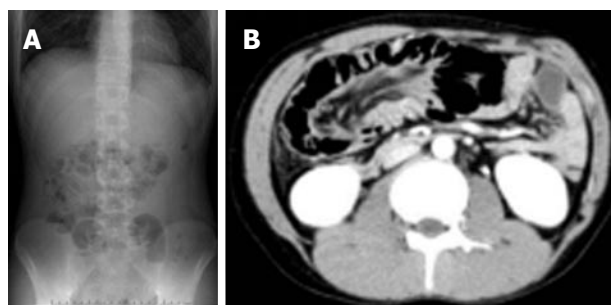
Abdominal radiograph. It showing multiple distended loops of small bowel with fluids and multiple air pockets (A) and computed tomography showing multiple gas-filled cysts, a streaky collection of air in the bowel wall, and an intussusception of the colon (B).
